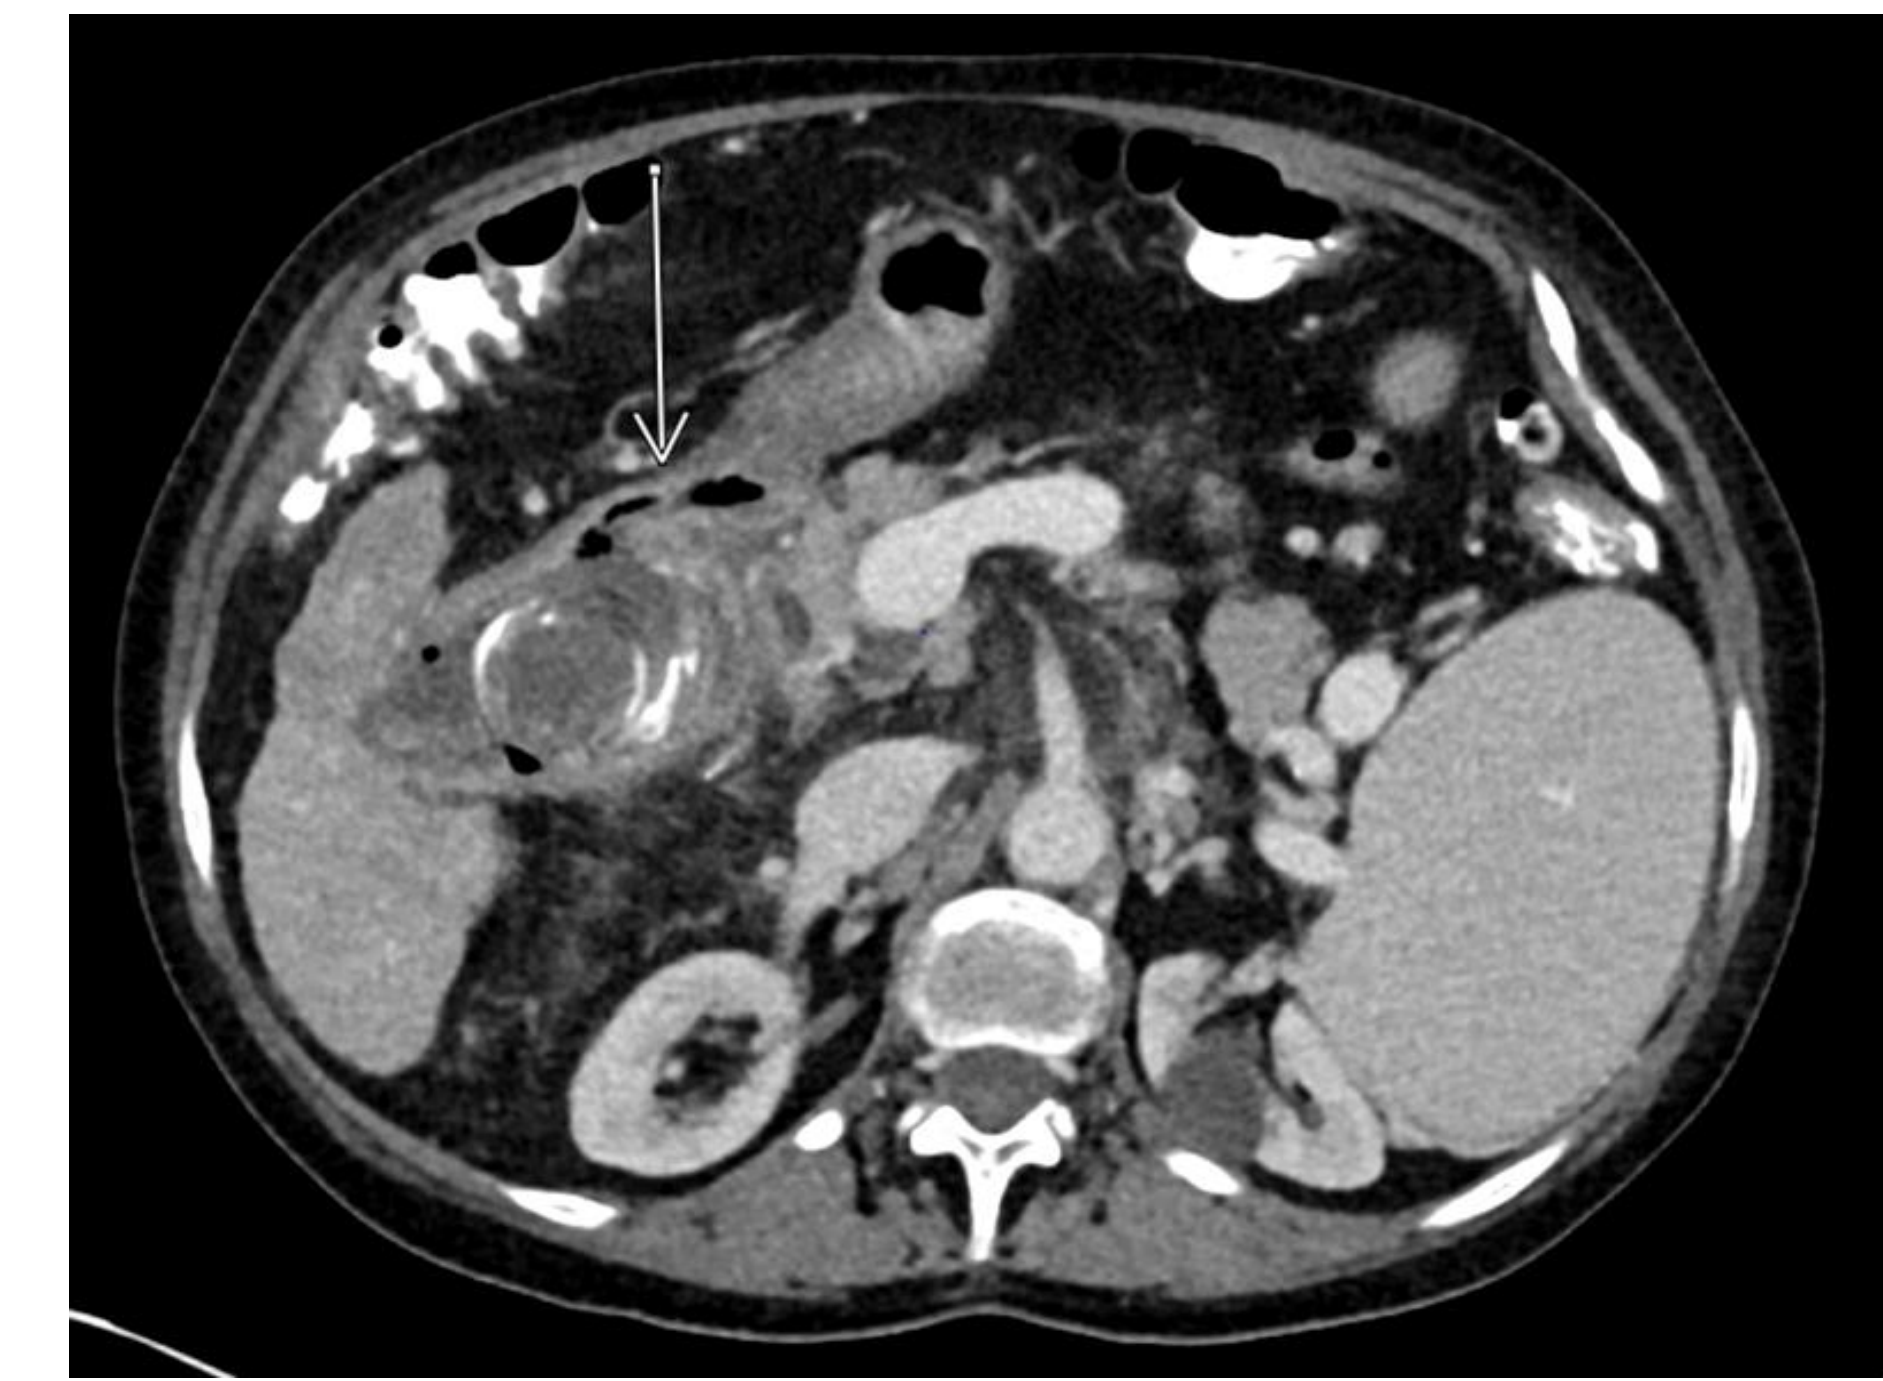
CT Demonstrating Fistulization of Gallbladder Neck Anteriorly into Duodenum
